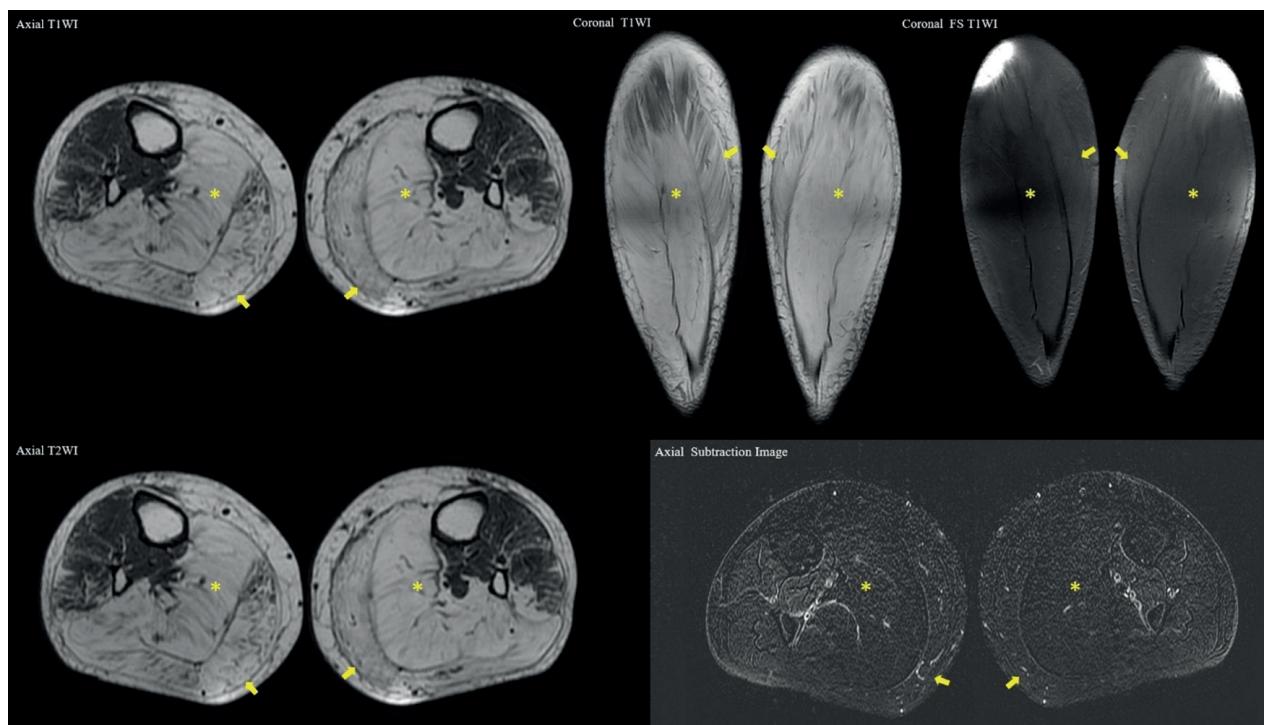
MRI images show hyperintensity and increased volume in the soleus (asterisks) and gastrocnemius muscles (arrows) on both axial and coronal T1W and T2W images, and signal suppression on coronal fat-suppressed T1W images. No pathologic contrast enhancement was observed on axial subtraction images.
